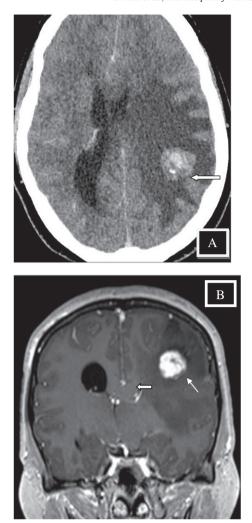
(A) Post contrast CT shows heterogenous lesion with intralesional calcification (arrows) and intense enhancement. (B) Coronal MRI post contrast image demonstrating avidly enhancing left parietal tumour (line arrow), with marked perilesional edema, mass effect, compressed left ventricle and rightward subfalcine herniation (block arrow).
